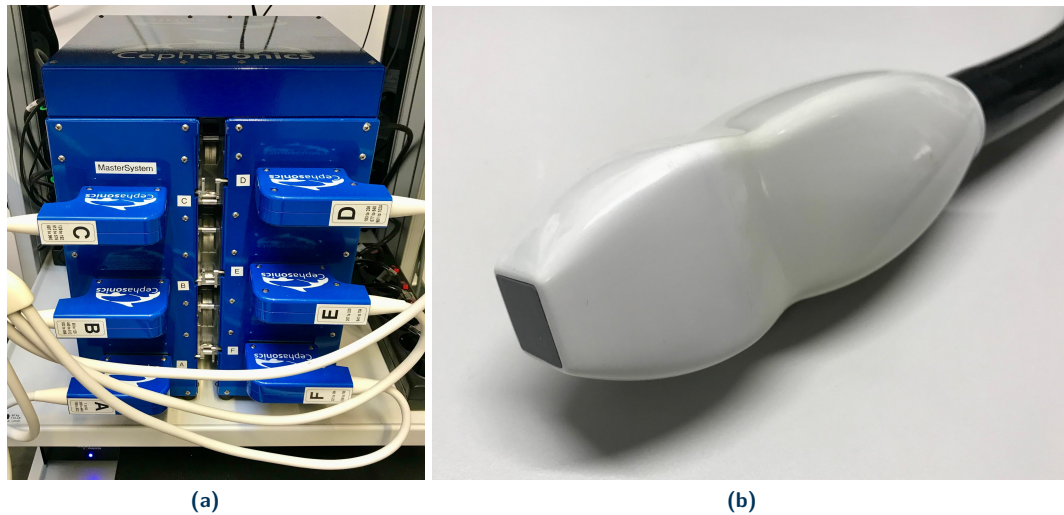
3D bespoke ultrasound system of the EDEN 2020 project. (a) The ultrasound system produced by Cephasonics, with all probe elements attached for 3D capabilities, and (b) Custom-produced 3D probe with a matrix array of piezoelectric elements, capable of capturing real-time volumetric images.
